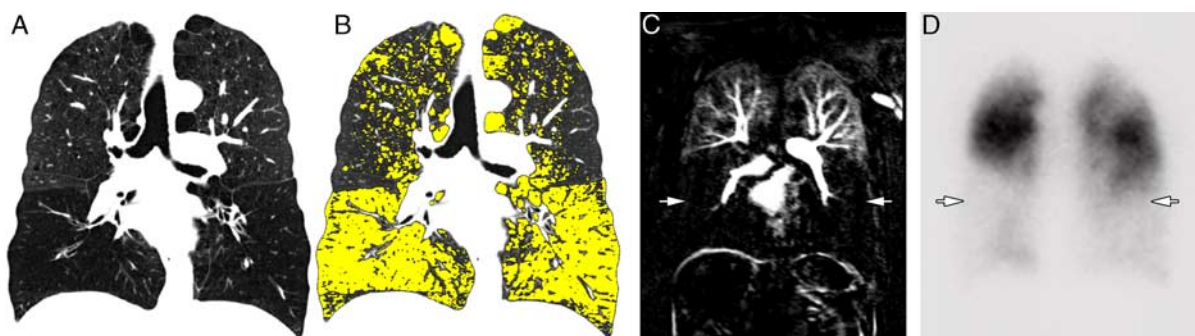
CT and MR perfusion scan of a 67-year-old male COPD patient (S7), GOLD status 3. A, CT scan in inspiration. B, Emphysema marked in yellow is mainly localized in the basal lung regions. Insp₋₉₅₀ for the whole lung is 42%, Insp₋₉₅₀ for right upper lobe, right middle lobe, right lower lobe and left upper lobe, left lower lobe is 24%, 60%, 60% and 17%, 58%, respectively. C, 4D Perfusion MRI (TWIST) 15 seconds after contrast injection. D, Coronal projection of lung perfusion scintigraphy. 4D MRI perfusion and perfusion scintigraphy both show matching perfusion defects mainly in the basal lung regions corresponding to the emphysema extent at CT (white arrows). COPD indicates chronic obstructive pulmonary disease.
